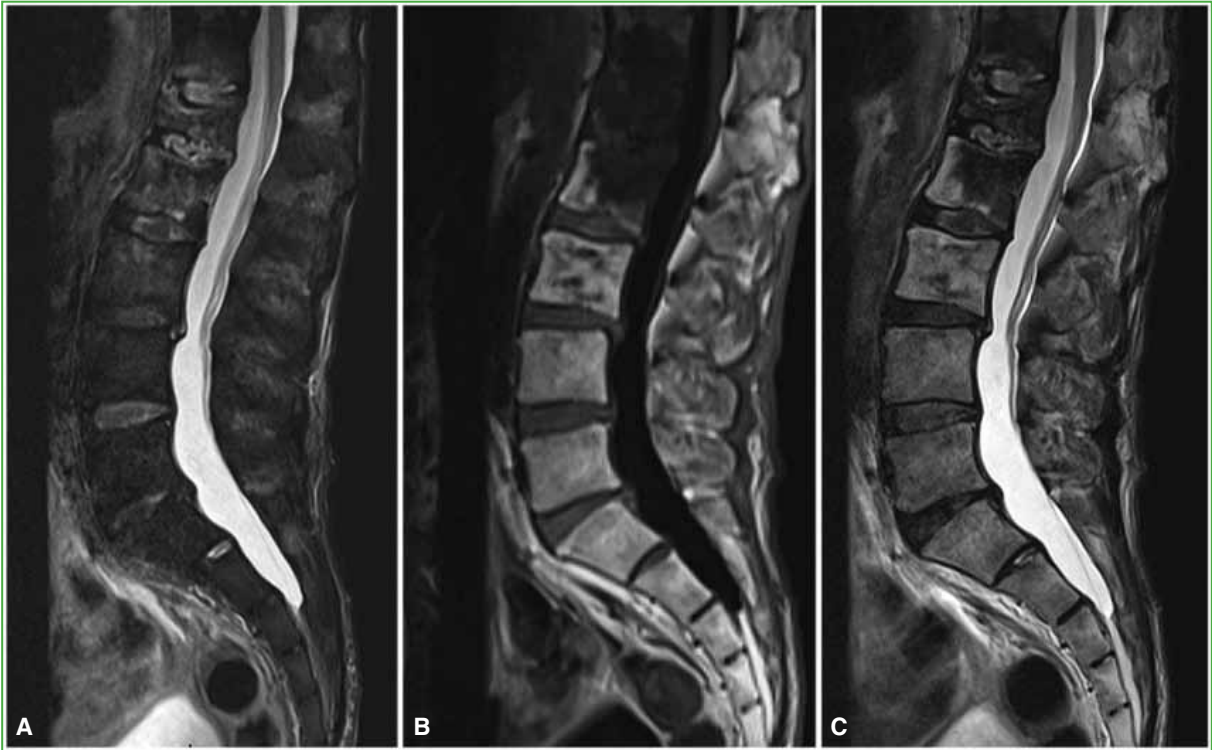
Magnetic resonance imaging of the lumbosacral spine, sagittal section. A. STIR sequence. B. T1-weighted sequence. C. T2-weighted sequence. Images compatible with spondylodiscitis of T12, L1 and L2 are observed.
